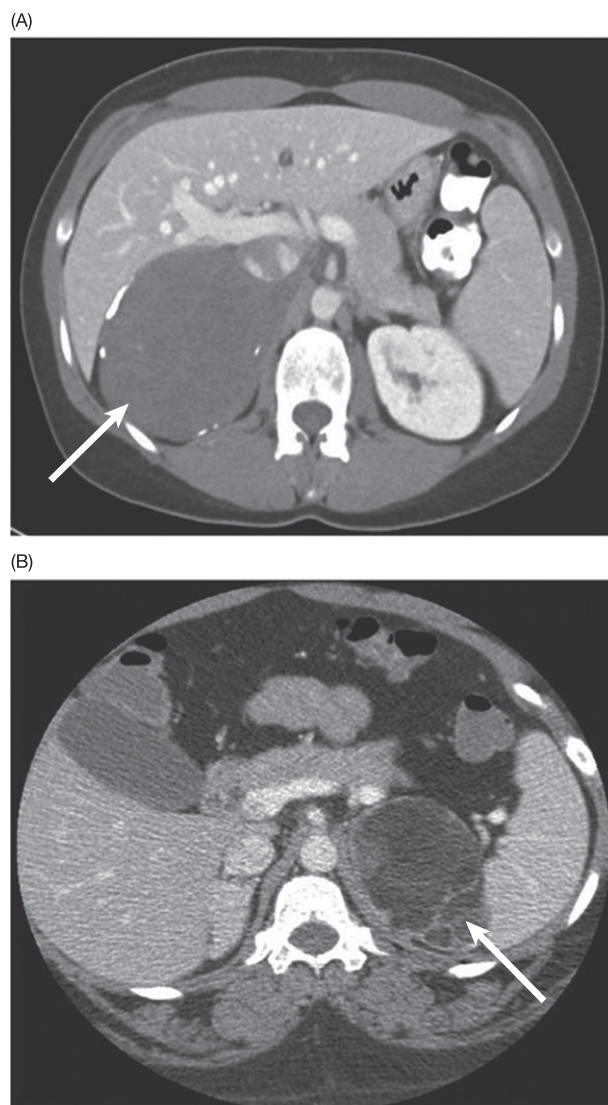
Computed tomography (CT) of a ganglioneuroma (A) and myelolipoma (B). CT with intravenous contrast of a ganglioneuroma of the right adrenal gland. The tumor has a low Hounsfield unit on contrast and is isointense with the muscle, and it has peripheral fine calcifications. CT with intravenous contrast showing a myelolipoma of the *left* adrenal gland. The mass is hypointense and isointense with the peritoneal fat and has interspersed higher attenuation tissue.
